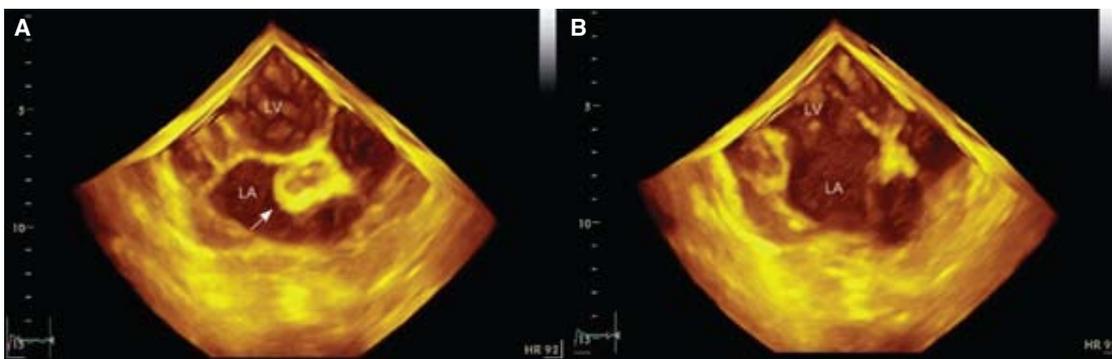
Four-dimensional transthoracic echocardiography showing the dynamic character of the pseudoaneurysm (A) expanding in systole and (B) collapsing in diastole. LA: Left atrium; LV: Left ventricle.
